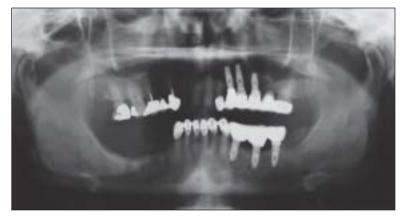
Panoramic radiograph obtained after extraction of implants.
